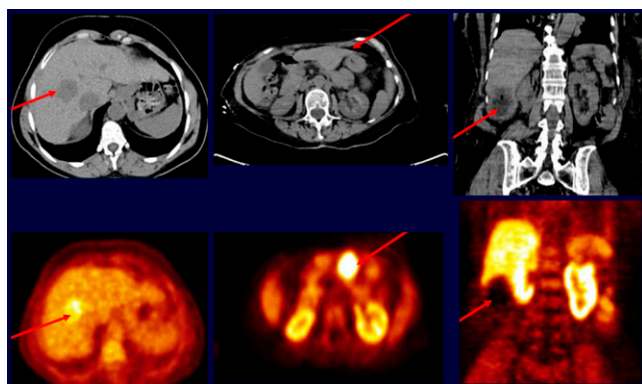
^{11}C -choline and ^{18}F -FDG PET/CT in hepatocellular carcinoma. Left: hypermetabolic lesion on ^{18}F -FDG. Middle: hypermetabolic lesion on ^{11}C -choline PET/CT. Right: hypometabolic lesion on ^{11}C -choline PET/CT.
